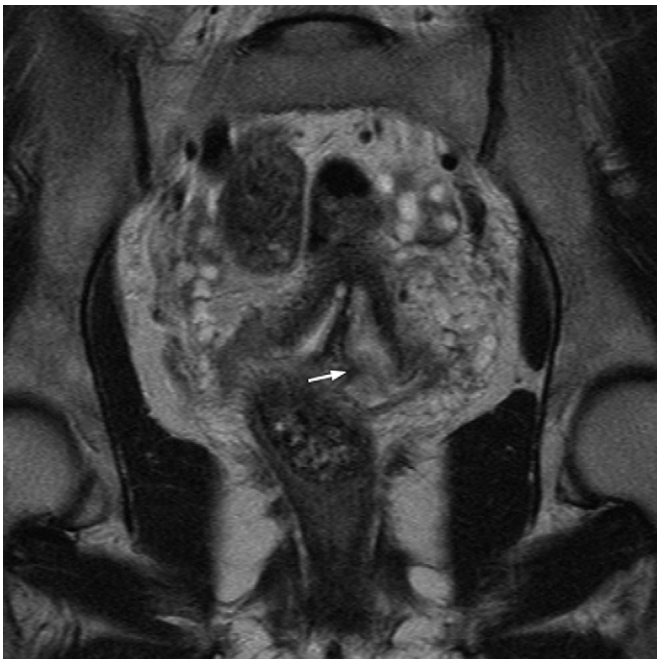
Coronal T2-weighted magnetic resonance image of the pelvis, again demonstrating 2 cervixes. An intermediate signal, lobulated mass is seen at the inferior aspect of the left-sided cervix, extending through the os (arrow).
